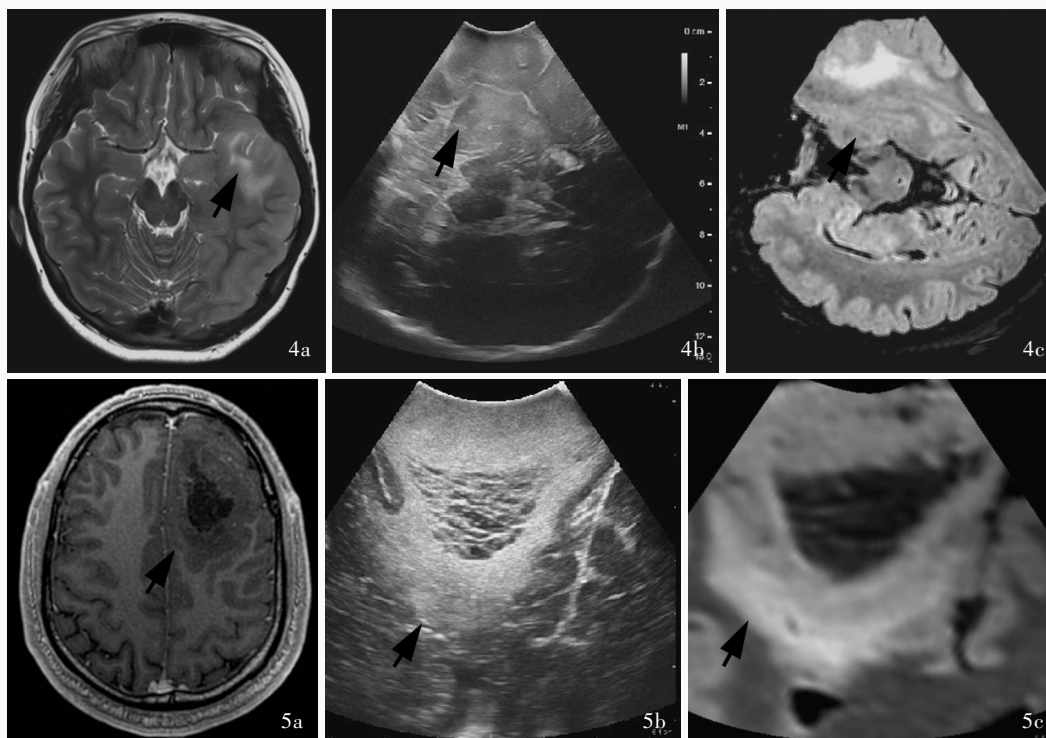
IDH 突变型星形细胞瘤(WHO 4 级),超声可见度分级 2 级,术前 MRI 和 iUS 所见 5a 横断面增强 T₁WI 显示左侧额叶占位性病变,呈低信号,弥漫浸润性生长,呈轻度斑片样强化(箭头所示) 5b iUS 显示病变呈高回声,内部呈混杂回声,病变可辨别,与周围正常脑组织边界不清,为超声可见度分级 2 级(箭头所示) 5c T₂-FLAIR 成像(超声同层面、同视野)显示病变呈高信号,内部囊性变呈低信号(箭头所示)
